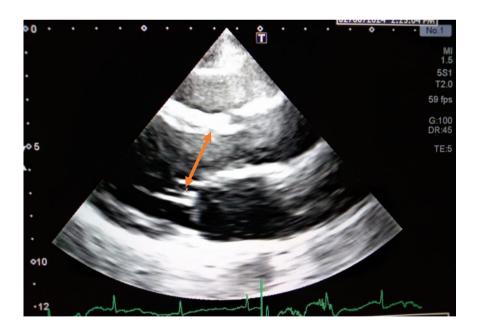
Echocardiographic image measuring c-septal distance in the parasternal long-axis view from the current study conducted at NICVD, Karachi.
